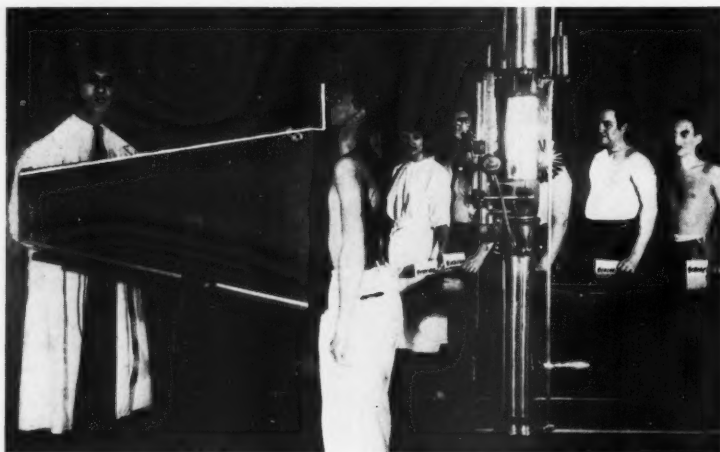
Each subject carries in his hand a card which bears on one side the clinical data and on the other a number. This card is inserted in a slot below the screen against which the subject places his chest. The chin is inserted in a notch at the top of the screen. It is most important that the chest be symmetrically placed and that the apices be fully exposed. The exposure is made in deepest inspiration. After the x-ray exposure has been made, the number on the card is photographed on the same film optically.
